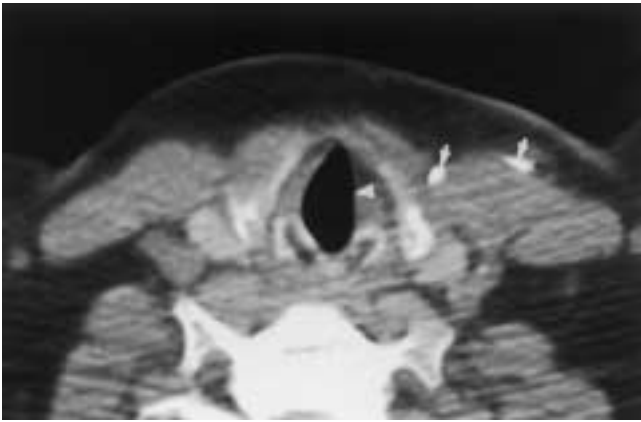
Vocal cord paralysis following insertion of a vagal nerve stimulator for refractory seizures. Axial CT reveals the radiopaque vagal nerve stimulator (*arrows*). The left vocal cord is paralyzed and does not abduct (*arrowhead*).
